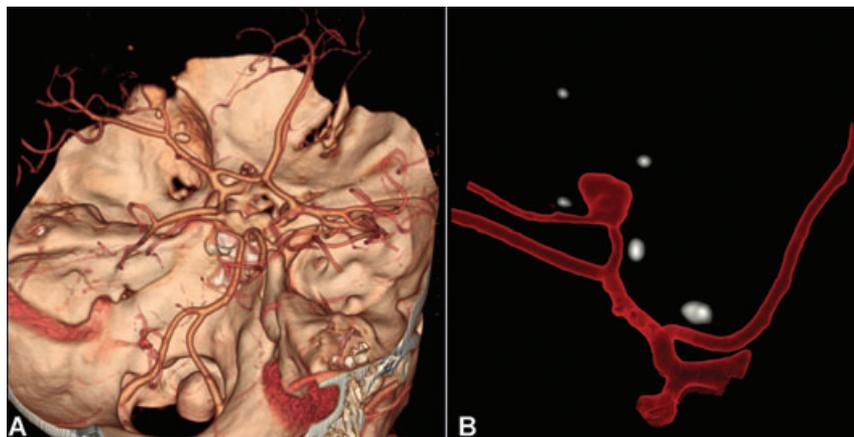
CTA. Volume rendering image, in oblique superior right view (A) confirms the presence of an aneurysm of a M2 branch of the left middle cerebral artery. Transparent volume rendering image, right view (B), shows the traumatic aneurysm with bone fragments (depicted in white) adjacent to its wall.
